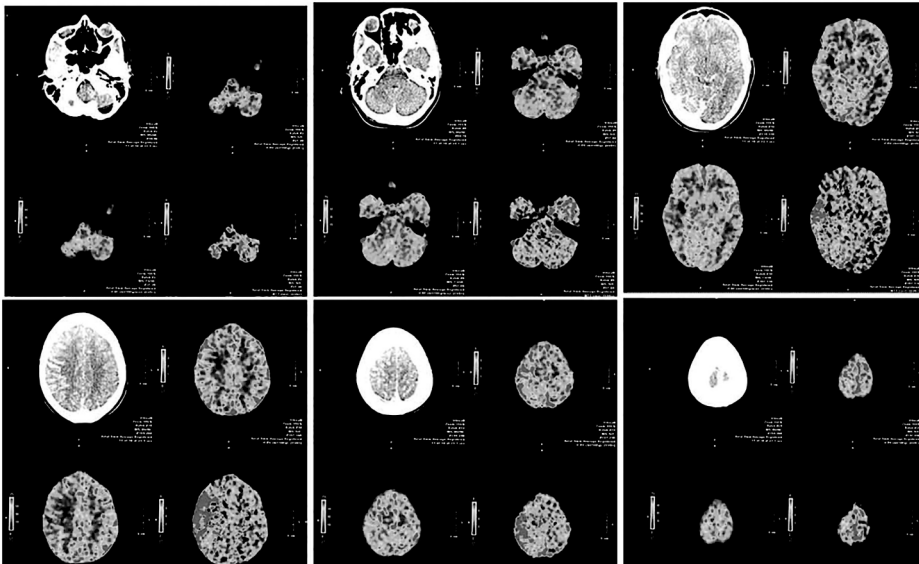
An example of whole brain CT perfusion. The coverage is from the skull base to vertex (6 levels are shown). The upper left image depicts the most caudal level, whereas the lower right image depicts the most cranial level.
